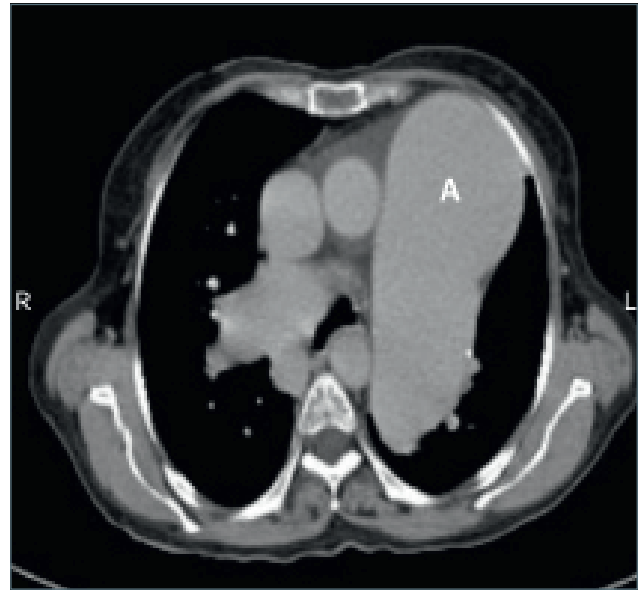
Showing huge pulmonary trunk (denoted by A) and markedly dilated left and right pulmonary arteries (denoted by B and C) on high resolution CT thorax.
